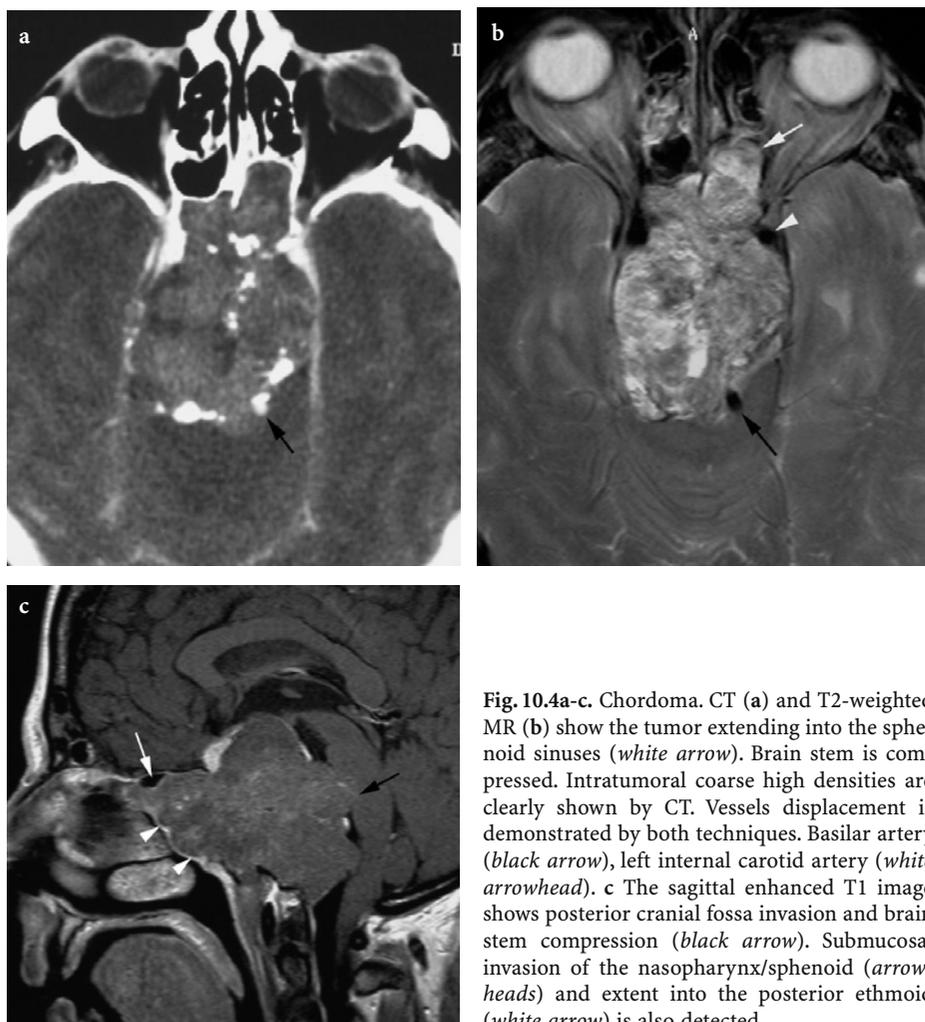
Chordoma. CT (a) and T2-weighted MR (b) show the tumor extending into the sphenoid sinuses (*white arrow*). Brain stem is compressed. Intratumoral coarse high densities are clearly shown by CT. Vessels displacement is demonstrated by both techniques. Basilar artery (*black arrow*), left internal carotid artery (*white arrowhead*). c The sagittal enhanced T1 image shows posterior cranial fossa invasion and brain stem compression (*black arrow*). Submucosal invasion of the nasopharynx/sphenoid (*arrowheads*) and extent into the posterior ethmoid (*white arrow*) is also detected
